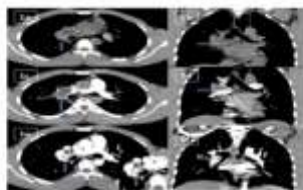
Contrast-enhanced CT of chest. Plain, 1st level in aortic phase (1A) and contrast (1B) showing middle mediastinal AVM (black arrow). Fig. 1C and 1D - CTPA axial (1C) and coronal (1D) showing early enhancing middle mediastinal AVM (black arrow) in pulmonary arterial phase. Fig. 1E and 1F - CTPA axial (1E) and coronal (1F) showing enhancing middle mediastinal AVM (black arrow) in the aortic phase. Inset images in the 1E & 1F showing the DVN phase scans.
